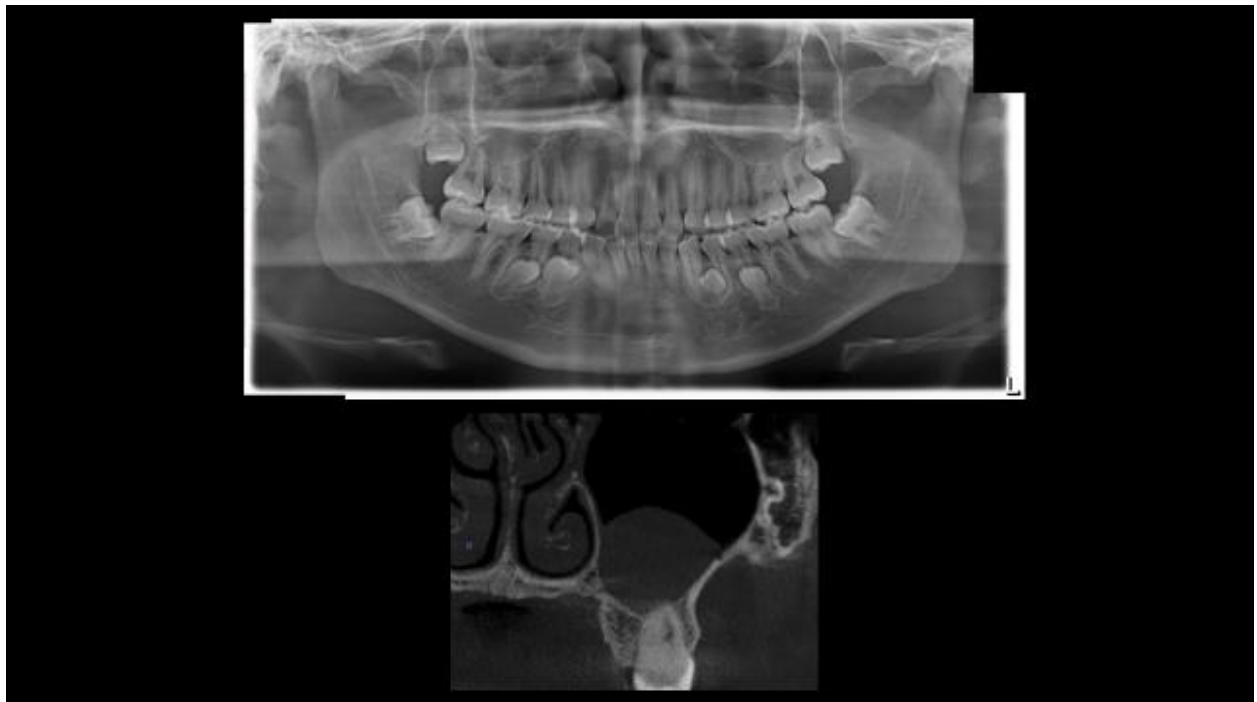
Mucus retention pseudocyst CBCT (bottom) visible on PAN (top)
